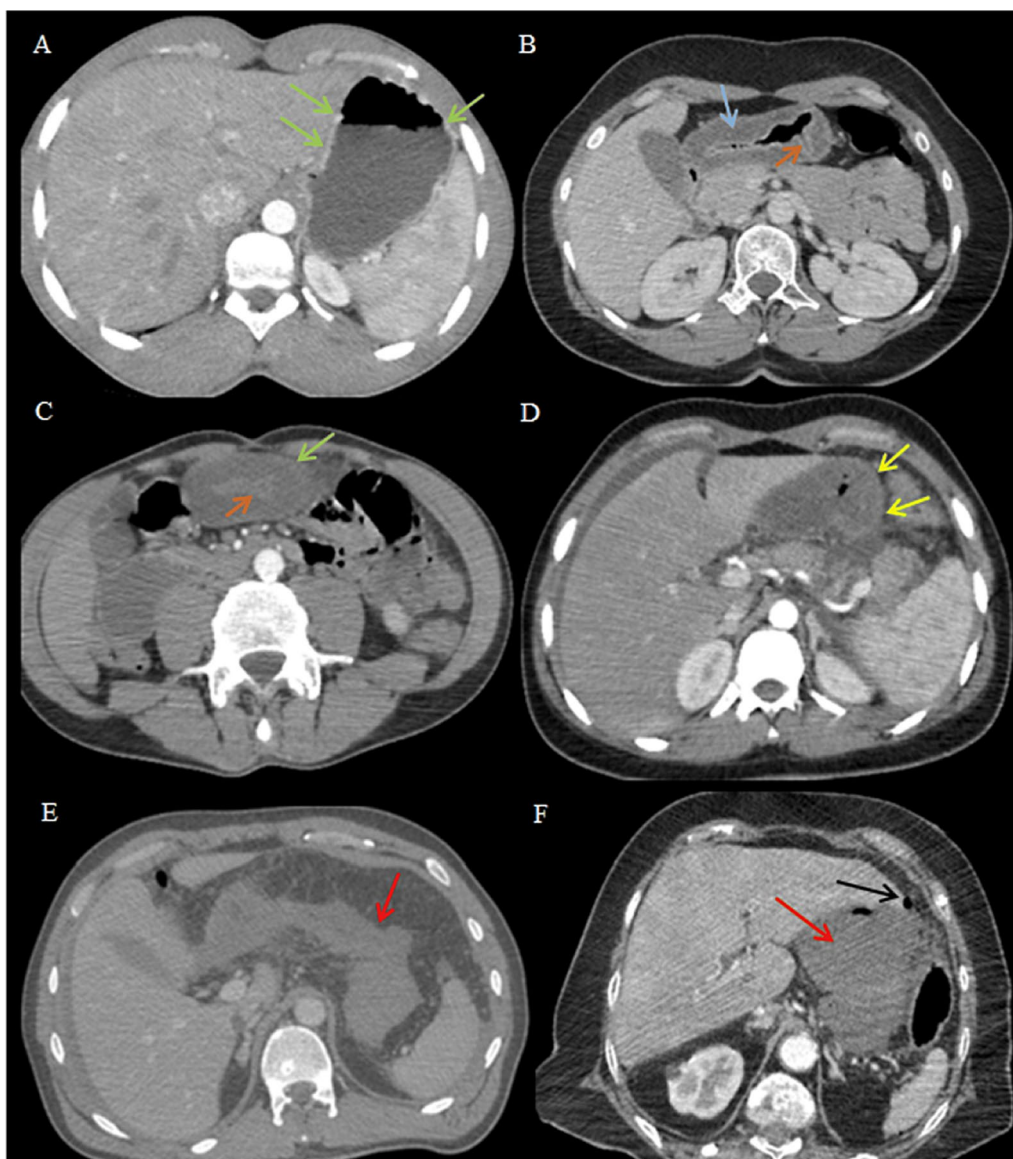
Features of computed tomography classification. A Grade 1: normal enhancement of gastric wall (green arrow). B Grade 2a: gastric submucosal edema (blue arrow) with normal mucosa enhancement (orange arrow). C Grade 2a: pyloric submucosal edema with mucosal (orange arrow) and extern wall enhancement (green arrow) target sign. D Grade 2b: non-enhancing mucosal necrosis with a normal enhancement of the extern layer of the digestive wall (yellow arrow). E Grade 3: non-enhancing gastric wall suggesting trans-parietal necrosis (red arrow). F Grade 4: gastric trans-parietal necrosis (red arrow) with peritoneal air bubble (black arrow) suggesting perforation
